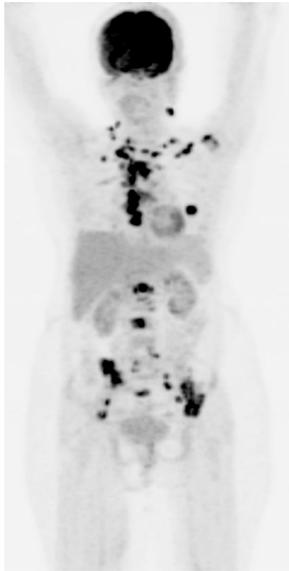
Maximum intensity projection (MIP) images of FDG PET/CT showing increased uptake in cervical, mediastinal, retroperitoneal nodes. Also increased uptake in multiple lung and bone lesions.
